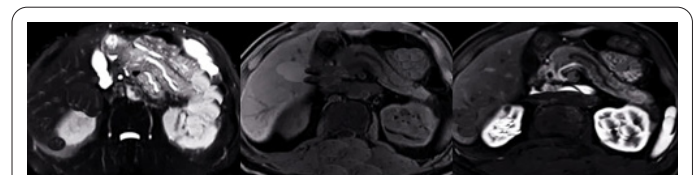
MRI images of patients with IgG4-related AIP. (Female, 61 years old, diarrhea due to abdominal distension after eating).
